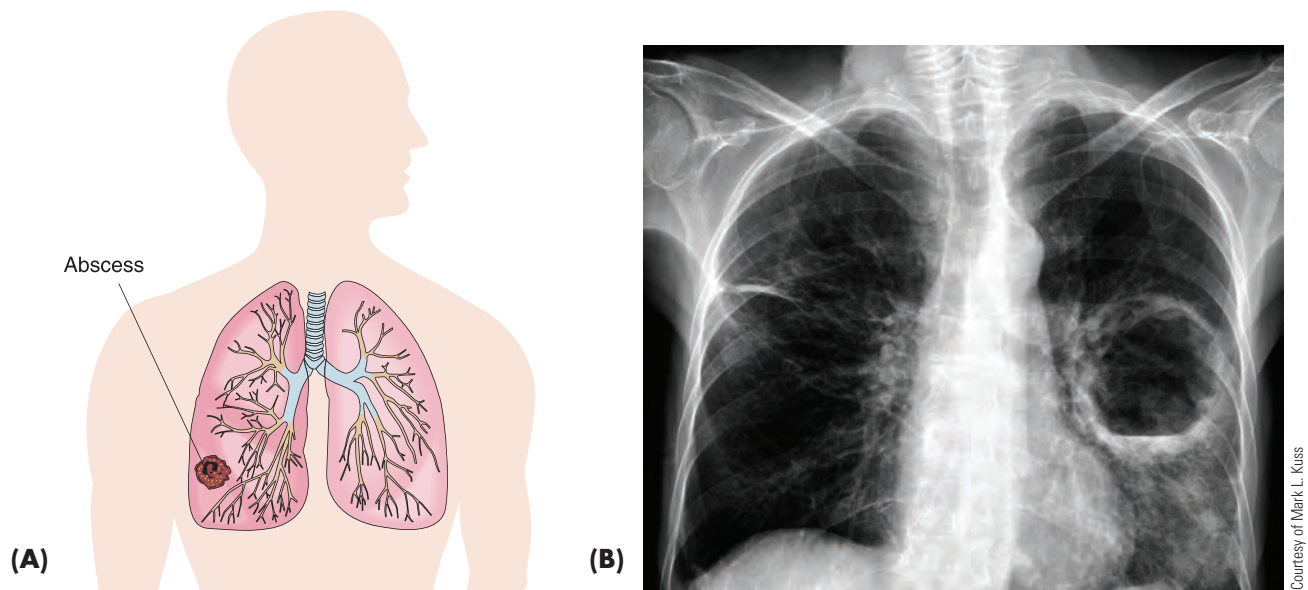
(A) Pulmonary abscess. (B) X-ray view of pulmonary abscess.
